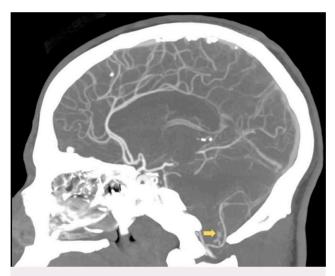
CTA, sagittal view, demonstrating an abnormal tangle of vessels in the right cervicomedullary junction (*arrow*).
